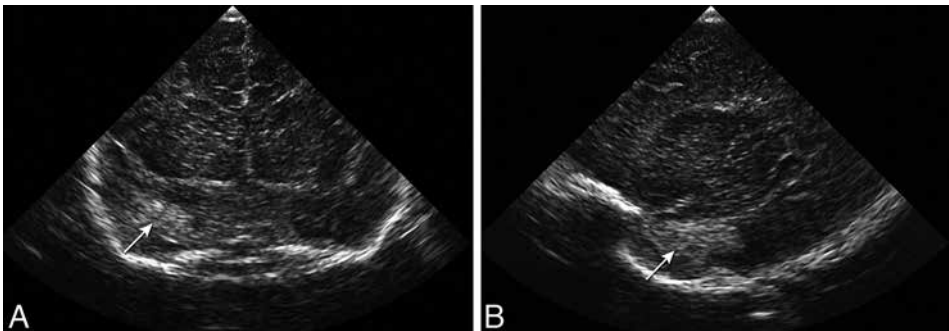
(A) Coronal and (B) parasagittal ultrasound scan in full-term neonate, presenting with convulsions, showing echogenic lesion in the right temporal lobe (arrow), reflecting hemorrhage.
